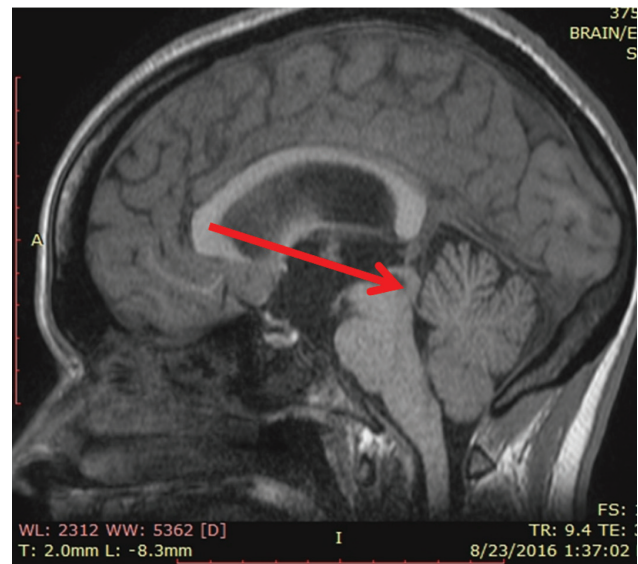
MRI: Aqueduct stenosis.
